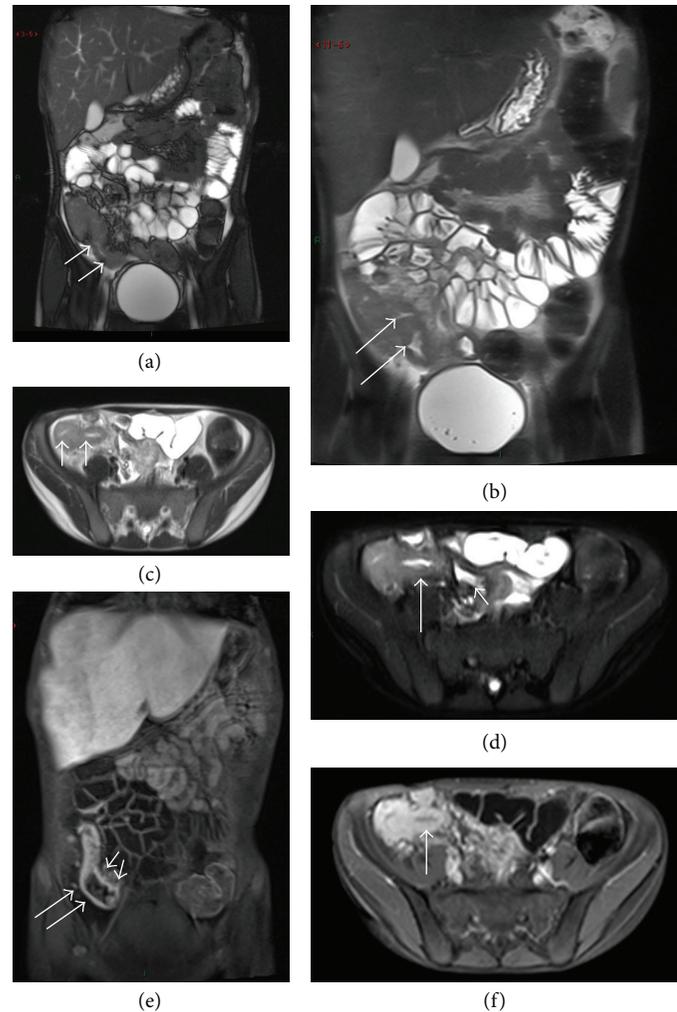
MR enteroclysis in a 21-year-old man with active Crohn's disease. Coronal true-FISP (a) and Haste (b) images show mucosal irregularity (arrows) as thin lines of high signal intensity, longitudinally, or transversely (fissure ulcers) orientated within the thickened in the terminal ileum consistent with diffuse ulcerations in Crohn's ileitis. Axial true-FISP sequence (c) detects wall thickening of terminal ileum as well as the cecal wall (arrows). Axial fat-suppressed T2 Haste sequence (d) MR image shows high signal intensity bowel wall (arrows) and fluid surrounding the distal ileum (small arrow). Coronal (e) and axial (f) contrasts GRE T1 with fat saturated images show marked contrast enhancement, with avid enhancement of the mucosa of the terminal ileum and cecal walls. Note the high signal intensity linear structure due to increased vascularity (small arrows in (e)) close to the mesenteric border of the involved small bowel segment, the so-called comb sign. These MR findings are indicative of active Crohn's disease.
